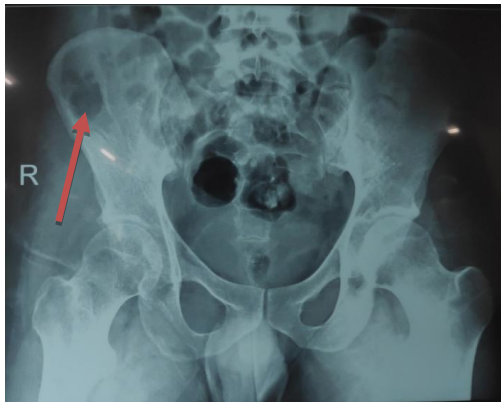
X-ray is an Antero-Posterior view of Pelvis. Bones exposed are Pelvis, Sacrum and head of femur bilaterally. Arrow indicates the site of bone graft from the iliac fossa.
